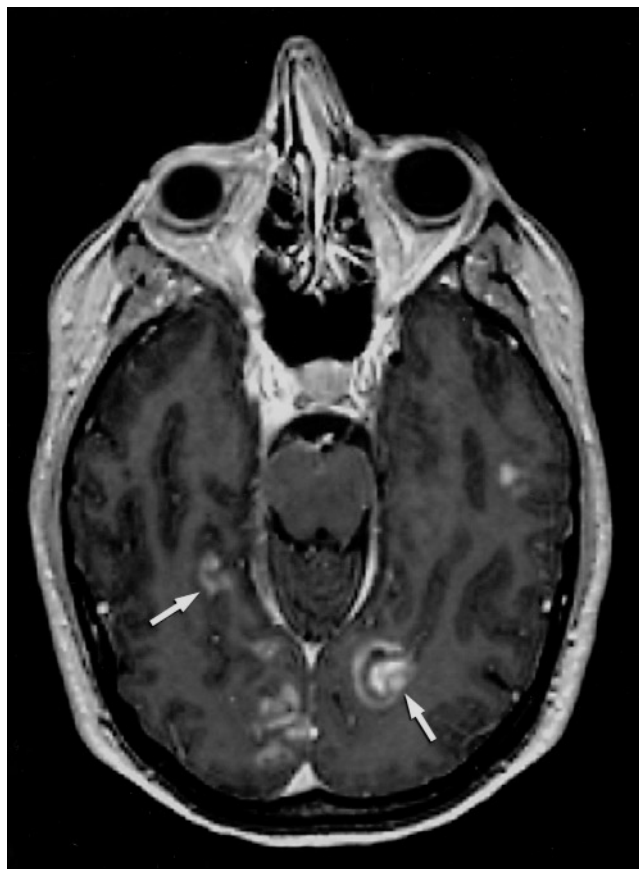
Axial T1 weighted magnetic resonance image (MRI) with gadolinium showing multiple enhancing lesions (arrows).
